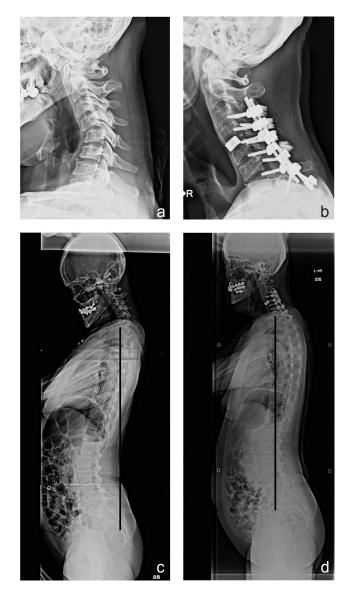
a: Plain lateral radiograph of the preoperative cervical spine showing 35° kyphosis (C2–C7 Cobb angle). b: Plain lateral radiograph of the postoperative cervical spine showing 8° lordosis at the level of C2–C7; a correction of 43° was achieved. c: Plain lateral radiograph of the preoperative total spine; C7 plumb line was displaced posteriorly, and SVA was -50 mm. d: Plain lateral radiograph of the postoperative total spine; C7 plumb line was shifted anteriorly, and sagittal alignment approached neutral balance. SVA was diminished to 0 mm. SVA: sagittal vertical axis.
